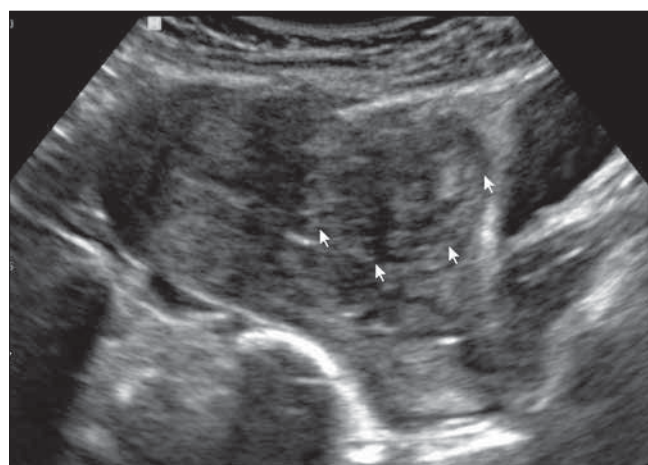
Transvaginal ultrasound scan performed after D&C demonstrated an empty uterine cavity and a hemorrhagic mass within the cesarean scar.
